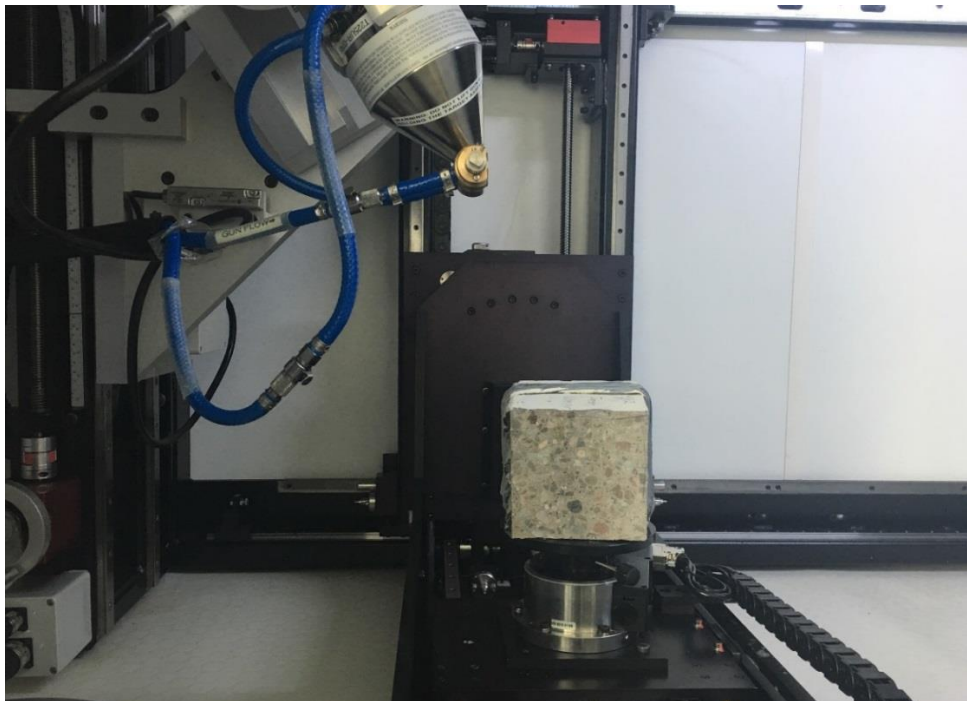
Setup of the CFRP representative cubes for CT scanning (before the radiation was turned on)
